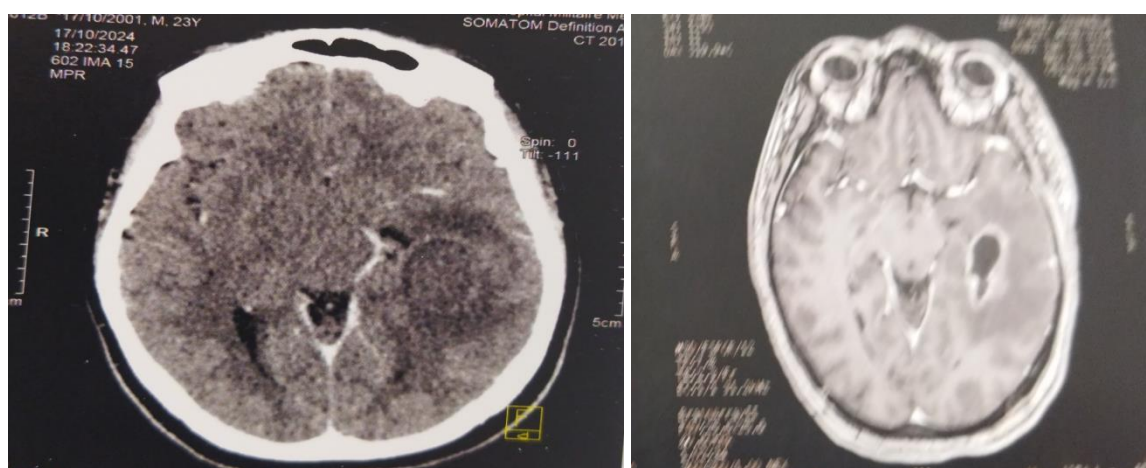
CT and MRI axial slices of brain showing left temporal abscess
